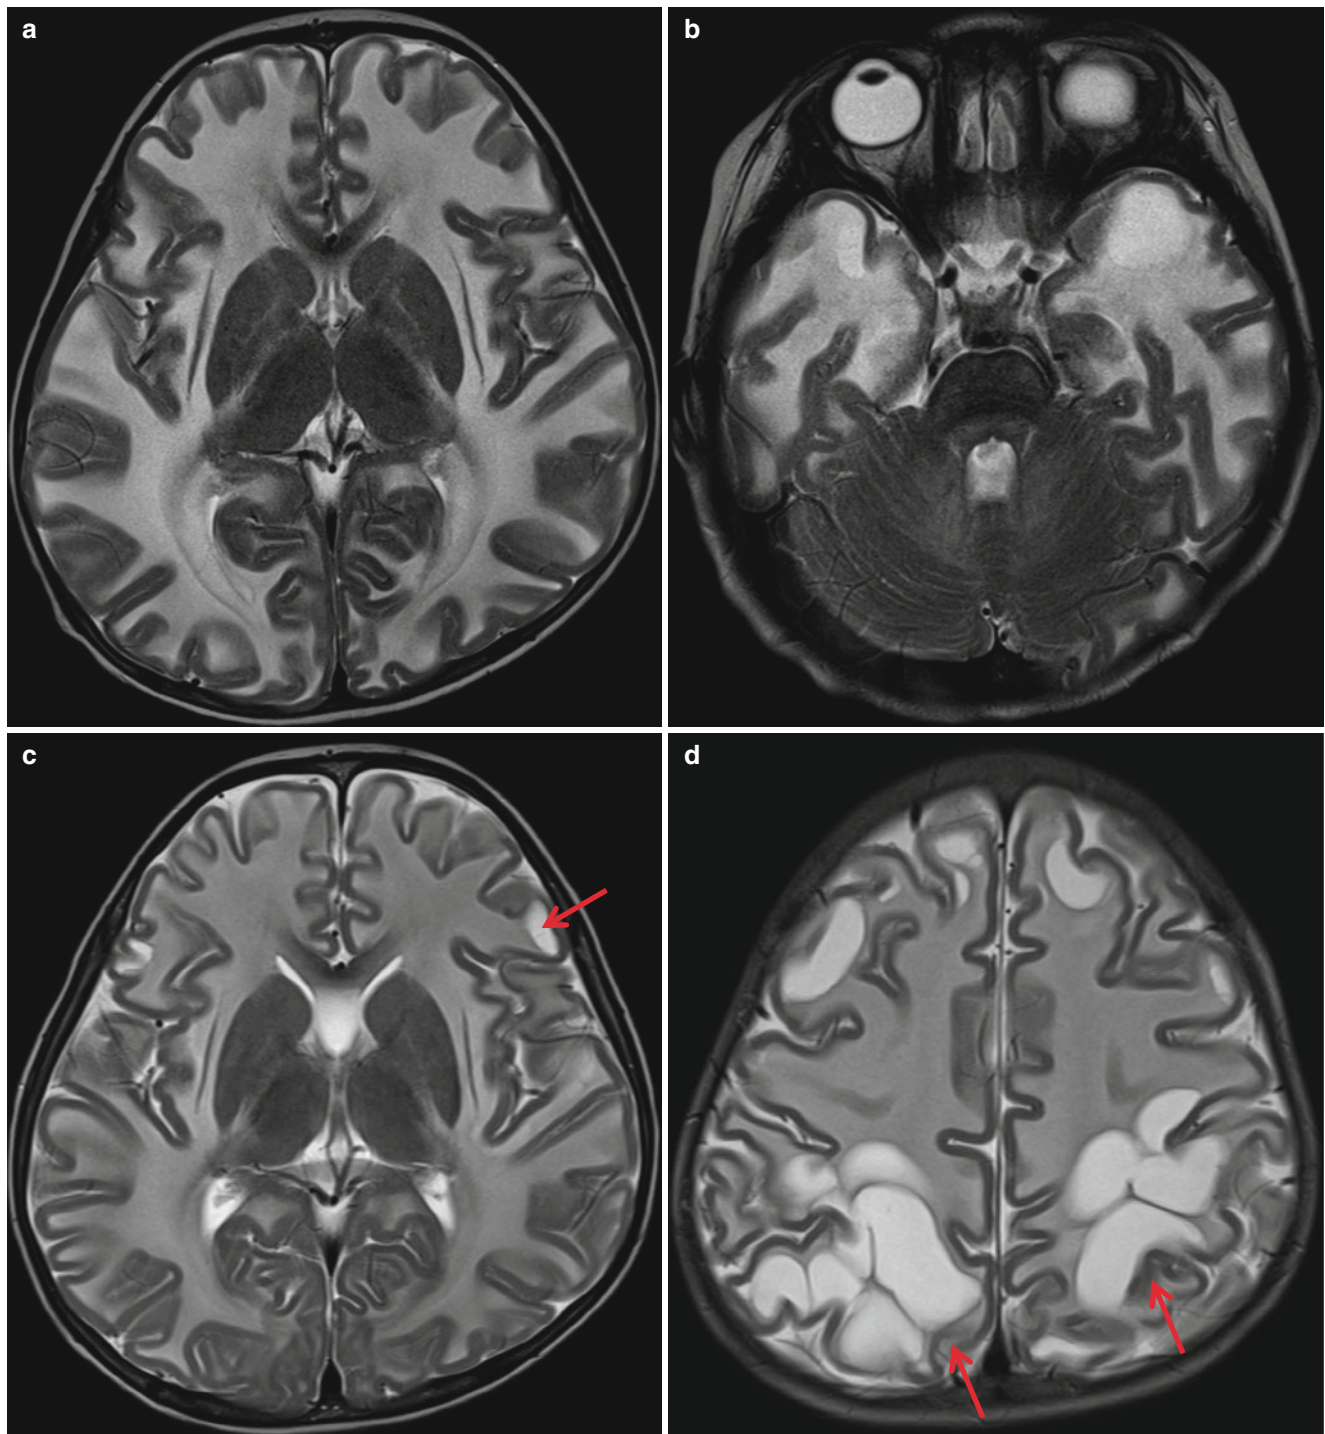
Megalencephalic leukoencephalopathy with subcortical cyst in a 13-month-old girl with macrocephaly, developmental delay, and seizures. (a, b) T2-weighted images show extensive demyelination of the entire white matters including the internal capsule. The white matter
